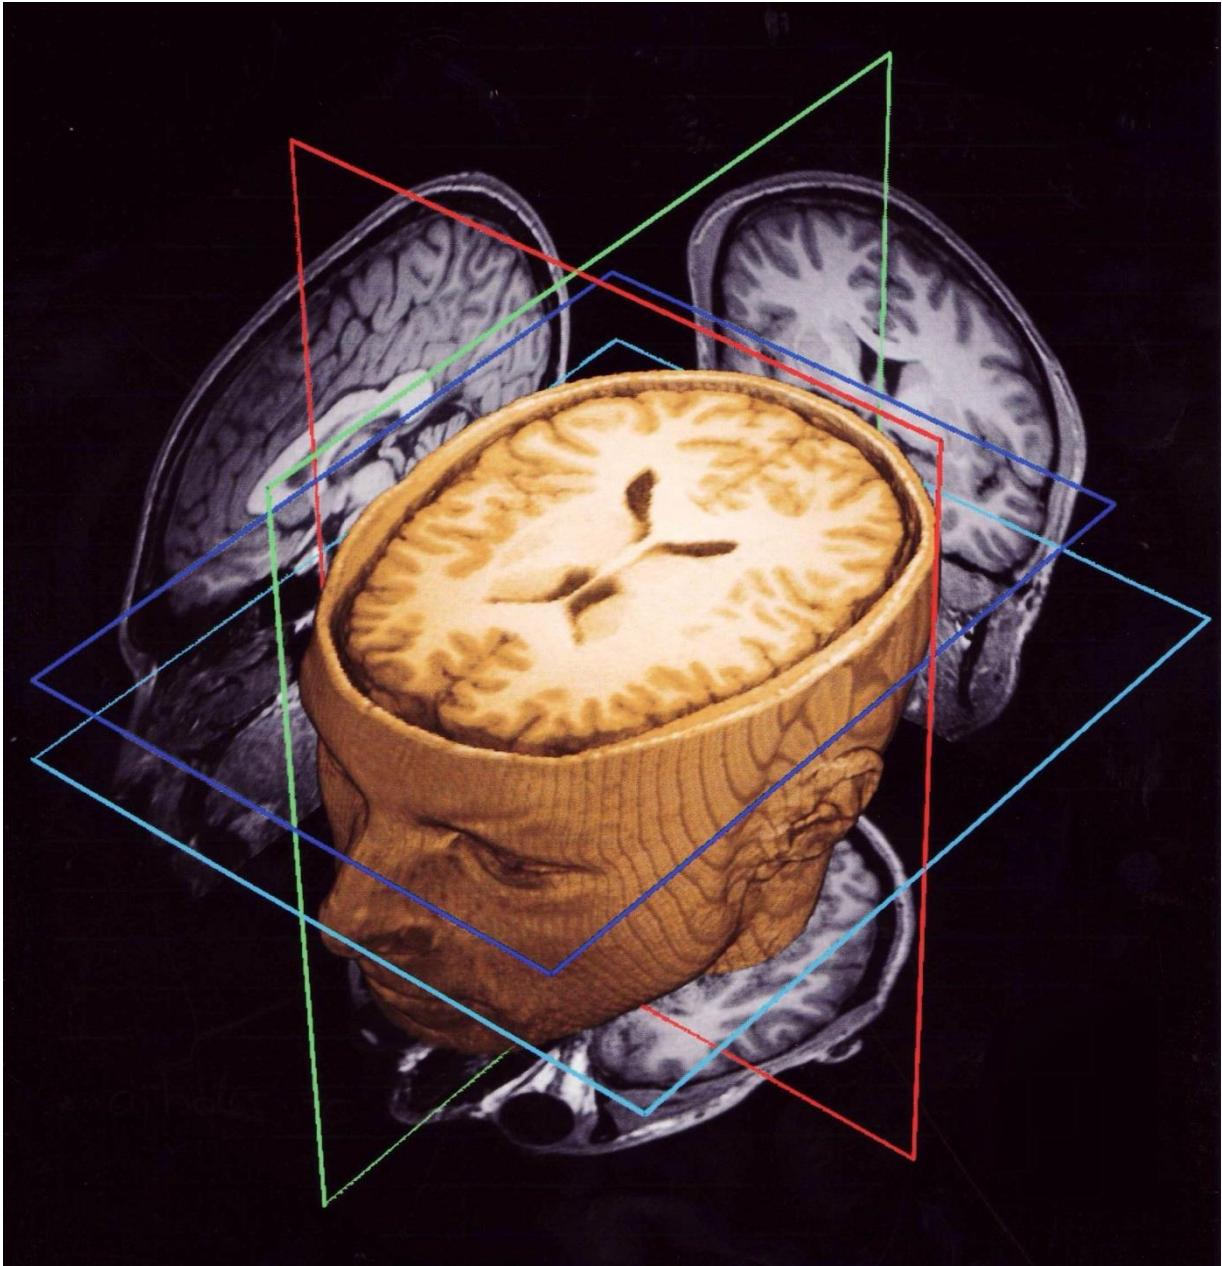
3D Head model cut on axial view and the corresponding coronal, sagittal and axial MRI scan images produced
